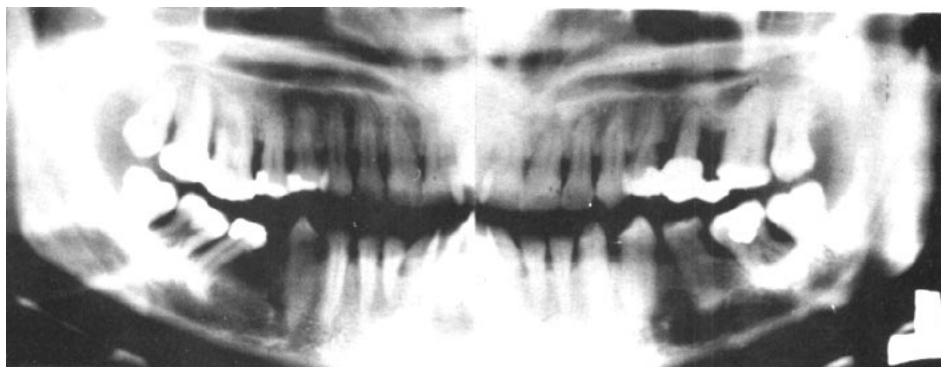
Panoramic radiograph of distally positioned bicuspid with curved roots.
